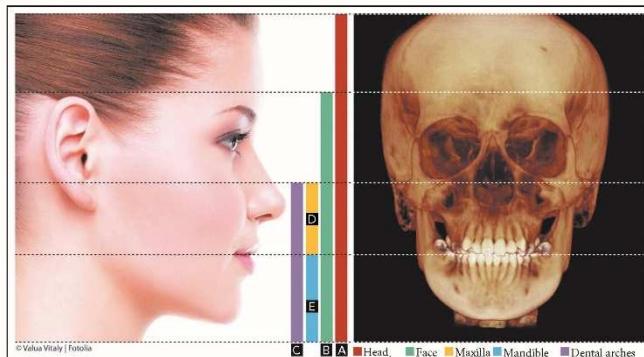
Cone-beam computed tomography field of view. It is cylindrical and determined according to its vertical extent. A) Field of view of the face and cranium; B) Field of view of the face; C) Field of view of the jaws; D) Field of view of the maxilla; E) Field of view of the mandible.
